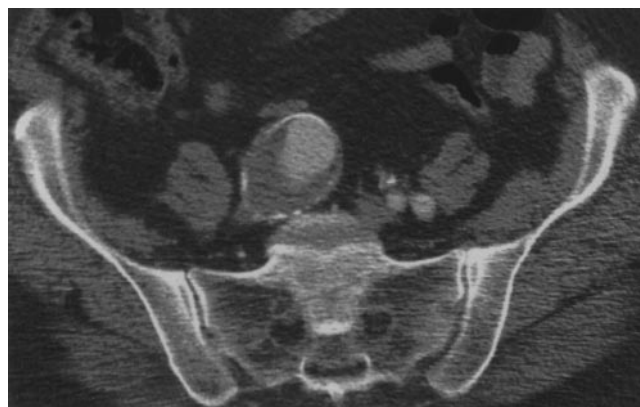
(Observation 1): Pelvic CT slice showing the right common iliac artery aneurysm, with endoluminal parietal thrombosis.
